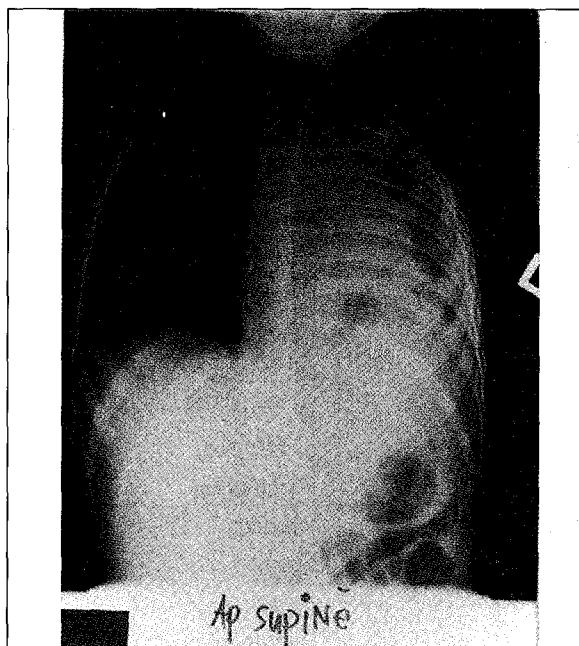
Chest radiograph showing collapse consolidation of the left lung
